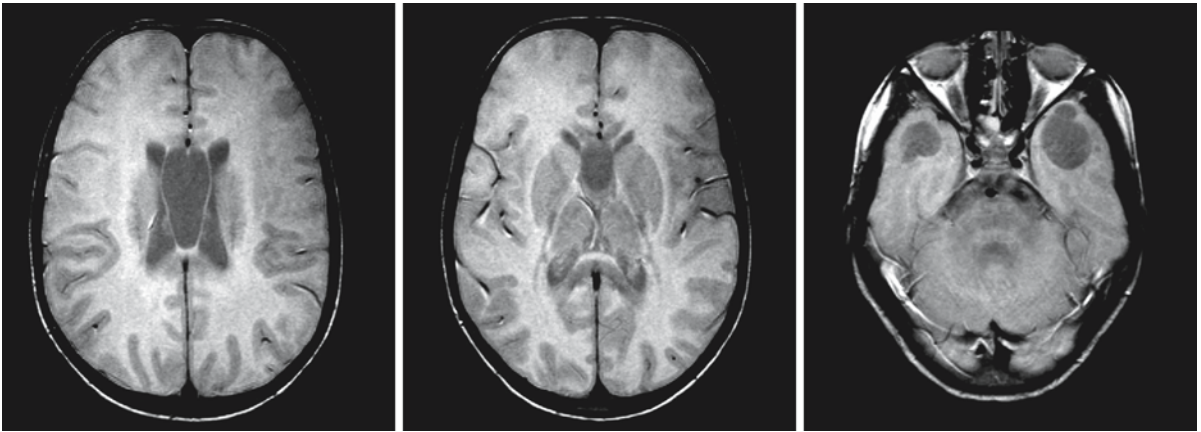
(continued). MRI series of a 6-year-old girl with MLC. The *upper row* of T₁-weighted sagittal images show the swollen white matter and the cysts in the frontal and temporal region. The U fibers in the posterior region of the cerebral hemispheres, corpus callosum, brain stem, and cerebellum are relatively normal in signal intensity. The *second and third rows* shows these features on axial T₂-weighted images. A large cavum septi pellucidi and cavum Vergae are visible. The corpus
